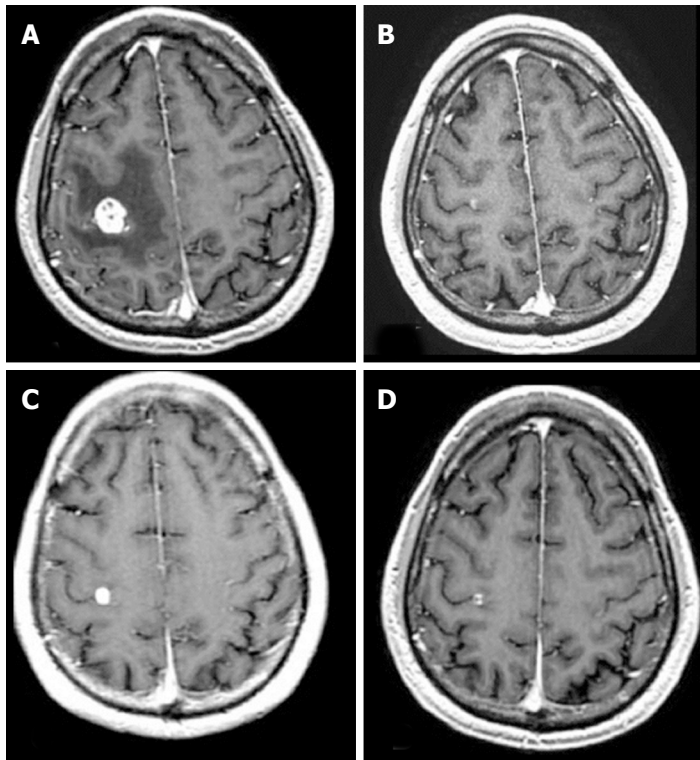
Follow-up axial enhanced T1-weighted magnetic resonance images of a brain metastasis from breast carcinoma treated with stereotactic radiosurgery in a 60-year-old woman. A: Pre stereotactic radiosurgery (SRS) magnetic resonance (MR) image; B: Initial follow-up MR image at 6 wk after SRS demonstrating an initial volume reduction; C: Follow-up MR image at 9 wk after SRS demonstrating a transient volume increase (pseudo-progression); D: Follow-up MR image at 12 wk demonstrating a final volume reduction.
